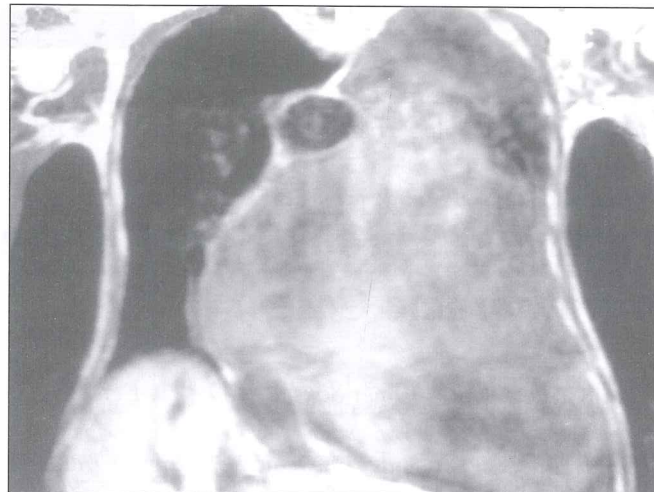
Magnetic resonance imaging of the chest showing a mass lesion involving almost the entire left hemithorax accompanied by mediastinal shift.
